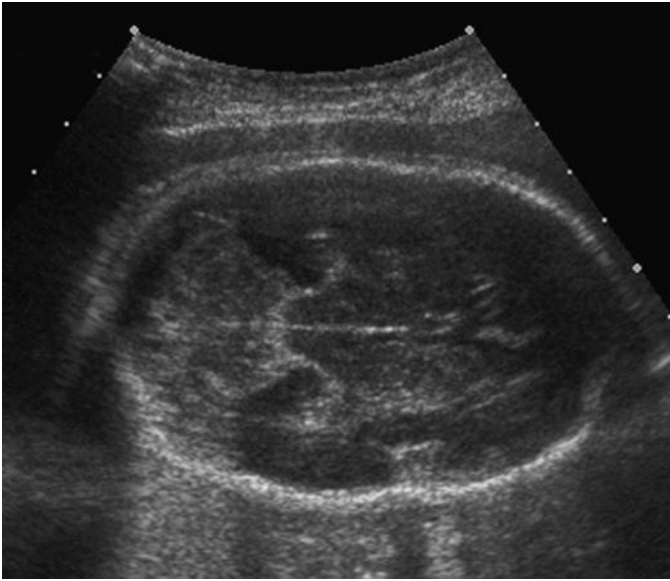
Sonogram of the fetal head commonly used for measurement of the biparietal diameter and head circumference. This case has a common variation referred to as dolichocephaly. The importance is that measurement of the biparietal diameter in such fetuses will tend to underestimate gestational age. Dolichocephaly may also be seen in cases of breech presentation, oligohydramnios, and myelomeningocele.
